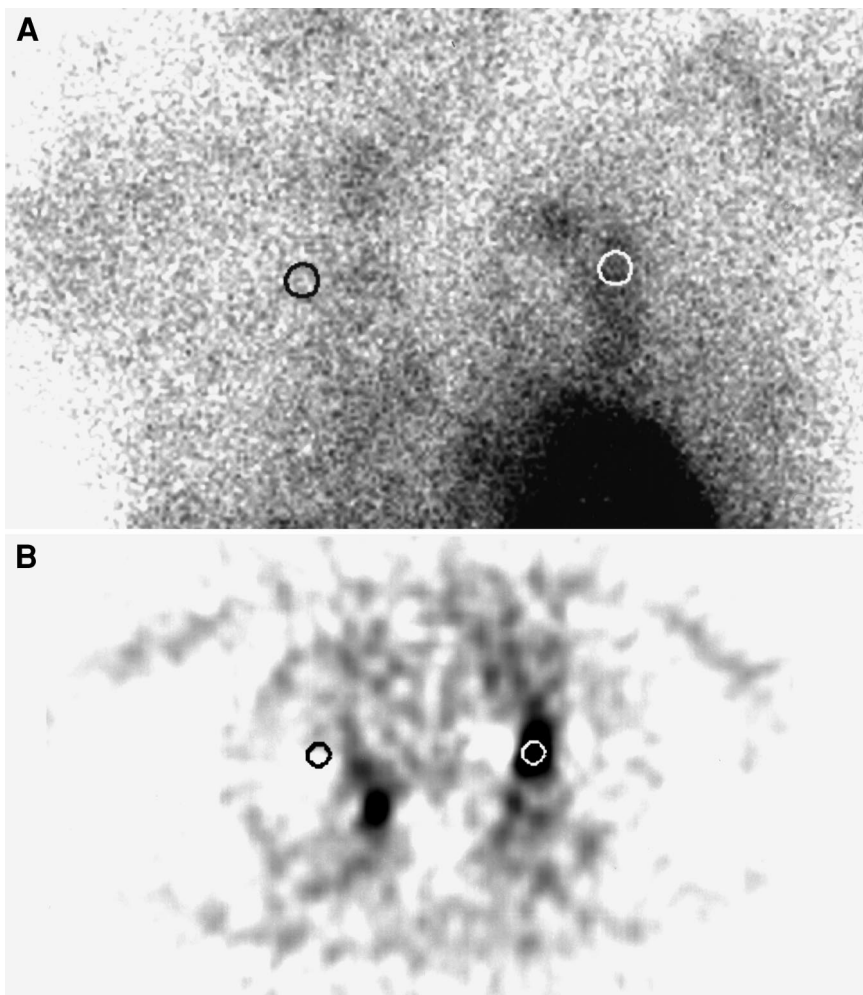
One-centimeter-diameter regions of interest drawn over tumors (white circle) and contralateral region (black circle) on spot images from ^{201}Tl scintigraphy (A) and on 5-mm-thick axial images from FDG PET (B).
